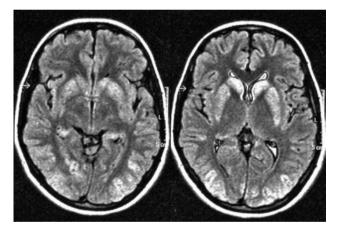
Axial FLAIR MRI images.
